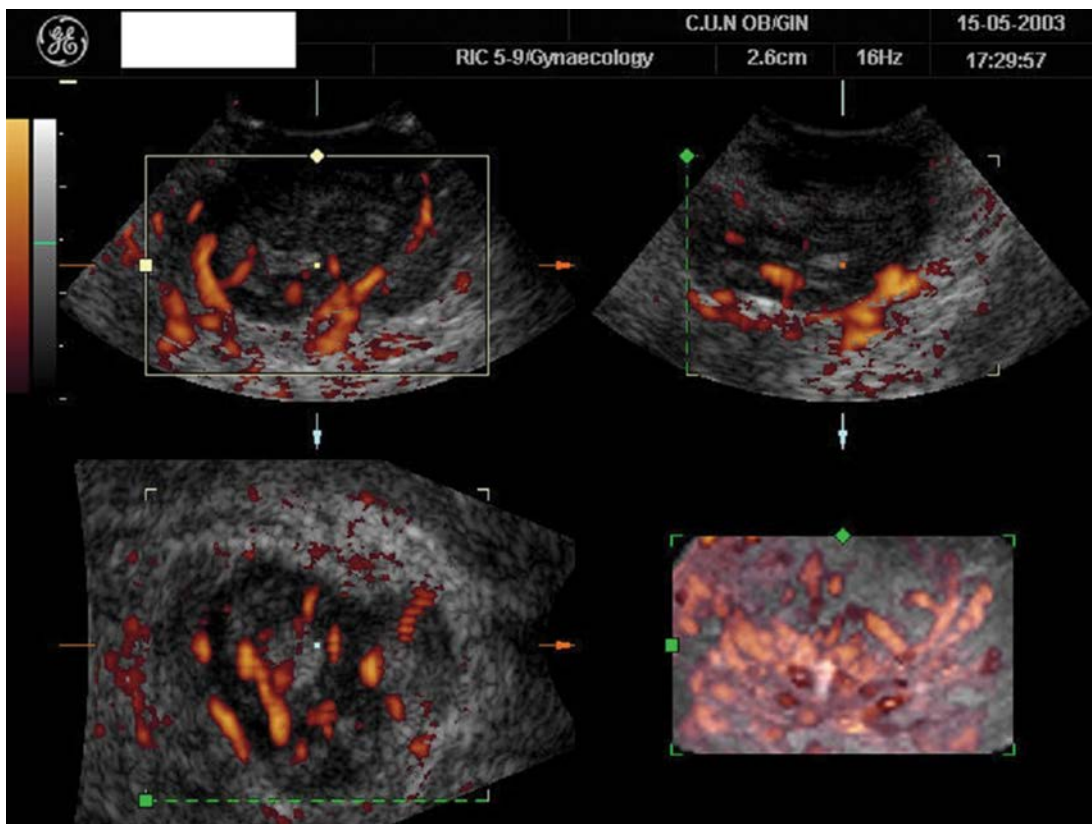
Same case as in [Figure 11.7](#), and with power Doppler evaluation it can be observed that the lesion is highly vascularized.
